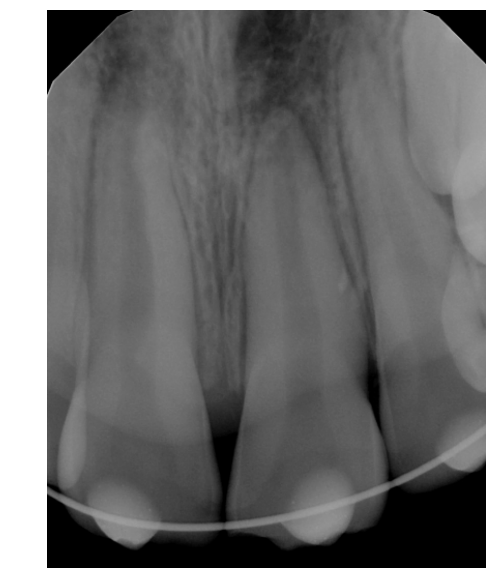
B: Radiograph after repositioning and splinting teeth
